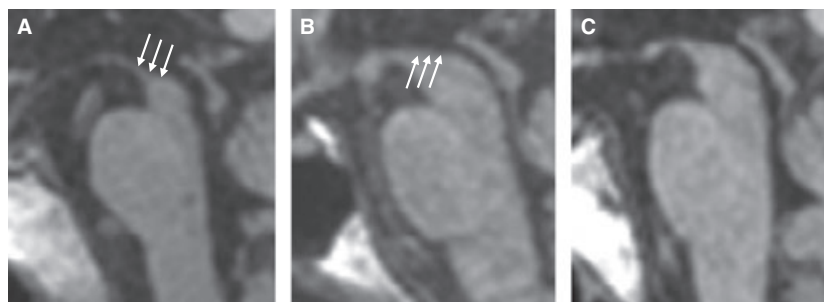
Mid-sagittal T1-weighted images of the rostral midbrain and pons of a patient with Richardson’s syndrome (A) with marked atrophy of midbrain tegmentum and a distinct *penguin sign* (arrows). This was not observable in a PSP-parkinsonism patient (B). (C) For comparison, the midbrain tegmentum of a patient with idiopathic Parkinson’s disease, with no abnormality (unpublished data).
